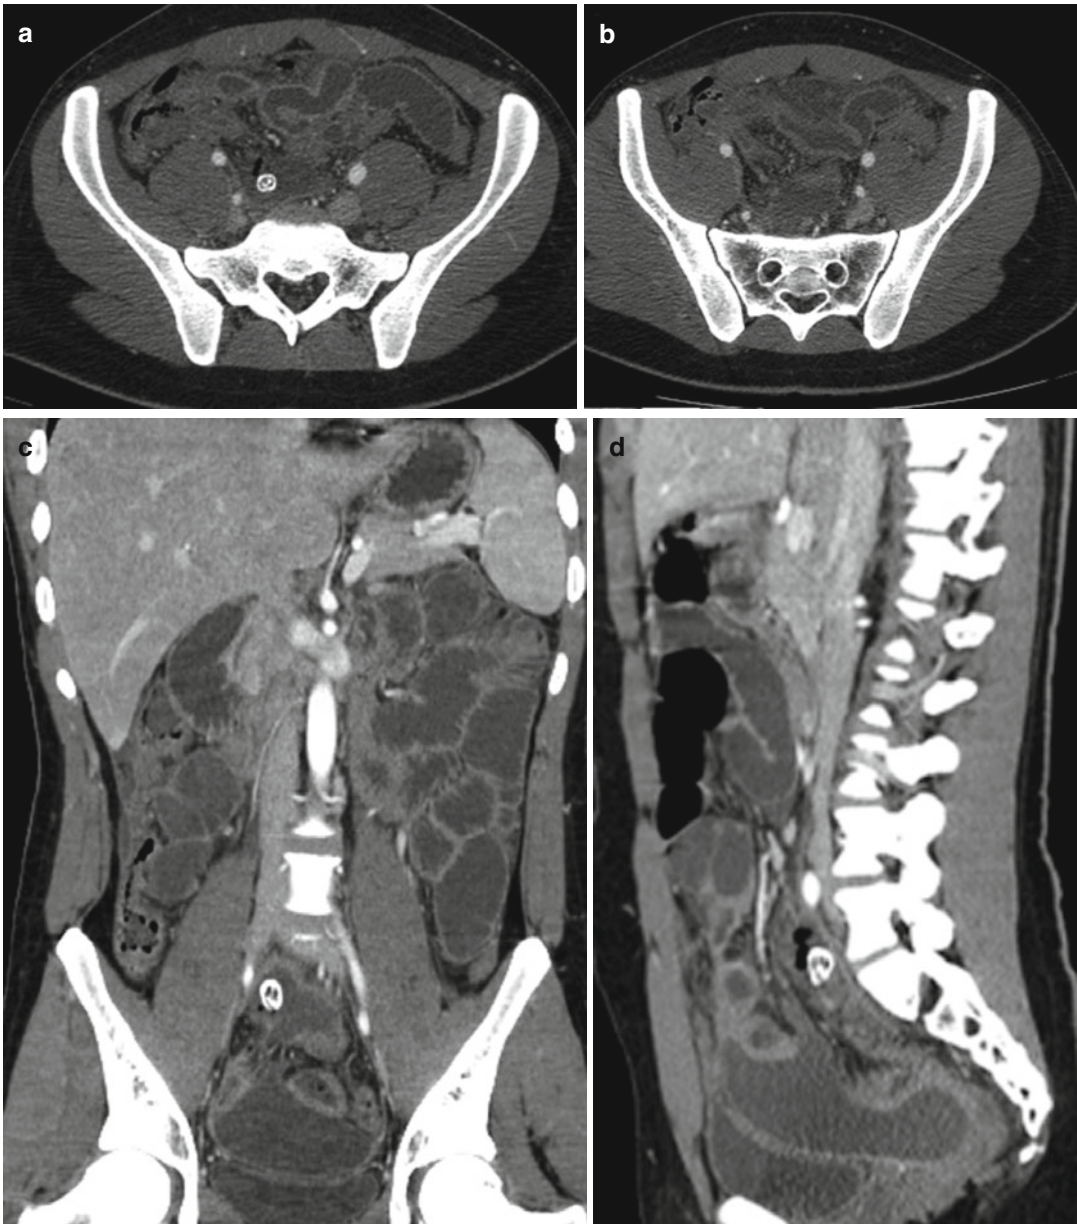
(a–b) CT, axial scans and (c–d) coronal and sagittal reconstructions: acute appendicitis. The figures show a thickened appendix with a wall diameter greater than 6.0–7.0 mm, periappendiceal inflammatory changes, and a calcified appendicolith in an individual with acute right lower
